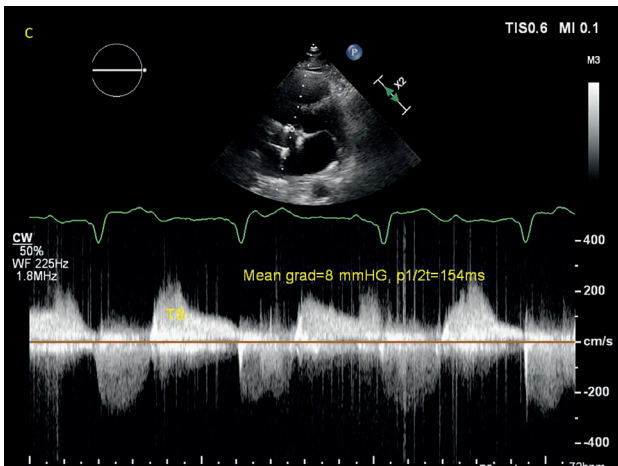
Continuous-wave Doppler of tricuspid stenosis jet showing high tricuspid mean gradient and pressure half-time (T1/2) values.
